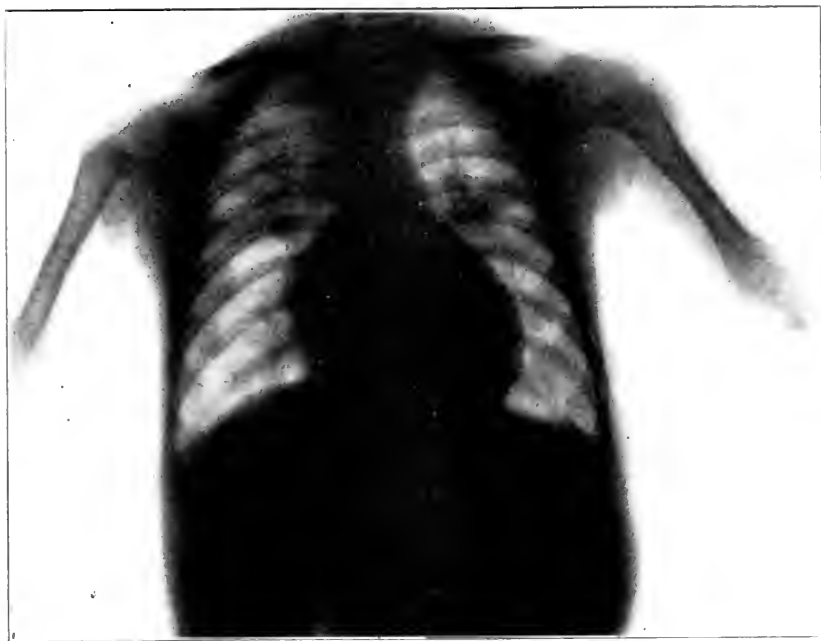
Case 2, pneumonia. When first seen this patient appeared to be suffering from some severe form of cerebral irritation. The child's head was thrown back; the respirations were exceedingly rapid, from 60 to 80 most of the time. Physical signs did not indicate the pneumonic areas involved and a meningeal condition was suspected. Lumbar puncture did not confirm this possibility. A roentgenogram showed distinctly a developing pneumonia, the signs of which soon appeared.
